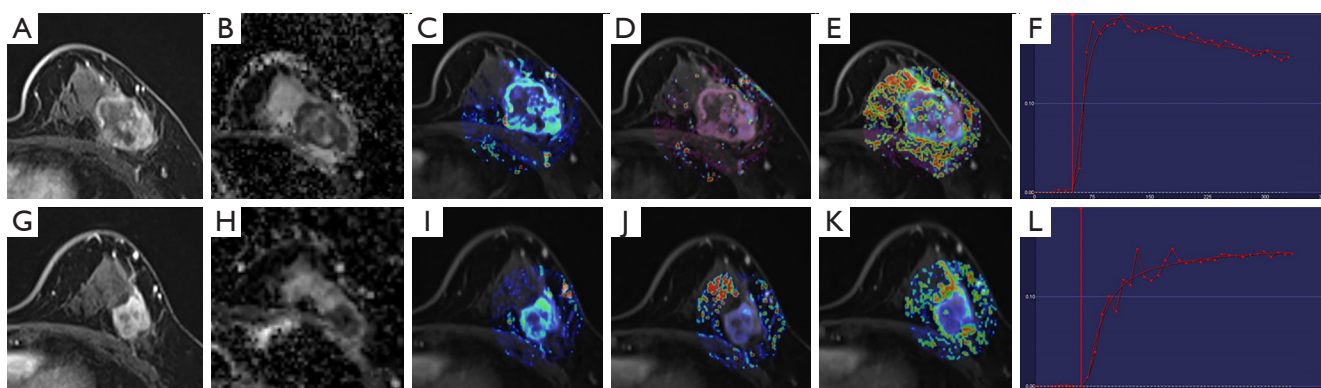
Representative case study: a 50-year-old woman with npCR after NACT. (A-F) Lesion before neoadjuvant treatment; (G-L) lesion after 2 cycles of neoadjuvant treatment. (A,G) Transverse compression lipid T1WI sequence shows the maximum tumor diameter is decreased by more than 30%, which indicates a good treatment response. (B,H) ADC image shows value of 0.624×10^{-3} vs. 0.632×10^{-3} mm²/s before and after 2 cycles of NACT. (C,I) K_{trans} pseudo-color image shows value of 0.319 vs. 0.305 min⁻¹ before and after 2 cycles of NACT. (D,J) K_{ep} pseudo-color image shows value of 0.837 vs. 0.821 min⁻¹ before and after 2 cycles of NACT. (E,K) V_e pseudo-color image shows value of 0.370 vs. 0.251 before and after 2 cycles of NACT. $\Delta\text{ADC}\%$, $\Delta K_{\text{trans}}\%$ and $\Delta K_{\text{ep}}\%$ after 2 cycles of NACT are significantly associated with npCR compared to the traditional method of measuring the changes in lesion size. (F,L) The average dynamic curve in the ROI with chi-square value of 0.031 vs. 0.021 before and after 2 cycles of NACT. npCR, non-pathologic complete response; NACT, neoadjuvant chemotherapy; T1WI, T1-weighted imaging; ADC, apparent diffusion coefficient; K_{trans} , transfer constant; K_{ep} , rate constant; V_e , relative extravascular extracellular space.
